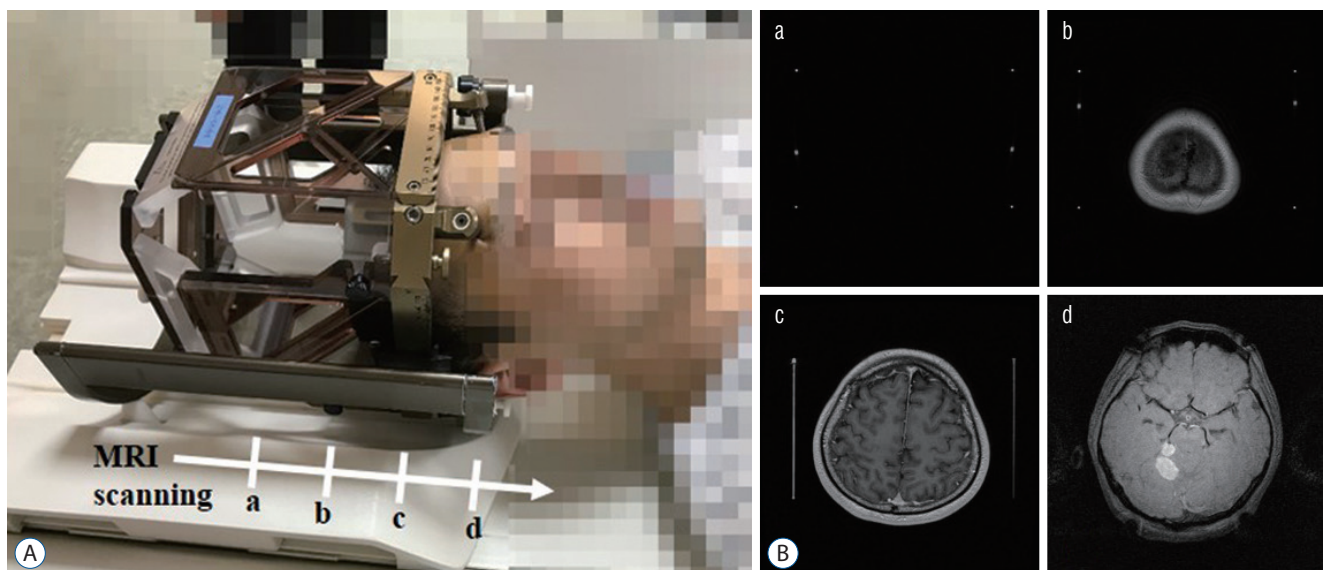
Mounting of indicator box and acquisition of magnetic resonance imaging (MRI). A : The MR-Indicator box is positioned on top of the head. B : The MRI evaluation should encompass both the indicator box and the infratentorial region that deviated from it. The MRI scanning is on the indicator box only (a), vertex (b), supratentorial area (c), and infratentorial target lesion with weakened magnetic signal (d).
